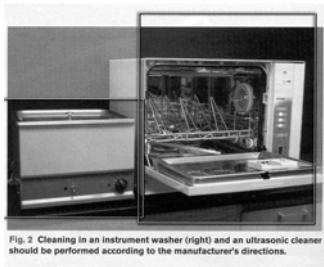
Cleaning in an instrument washer (right) and an ultrasonic cleaner should be performed according to the manufacturer's directions.
